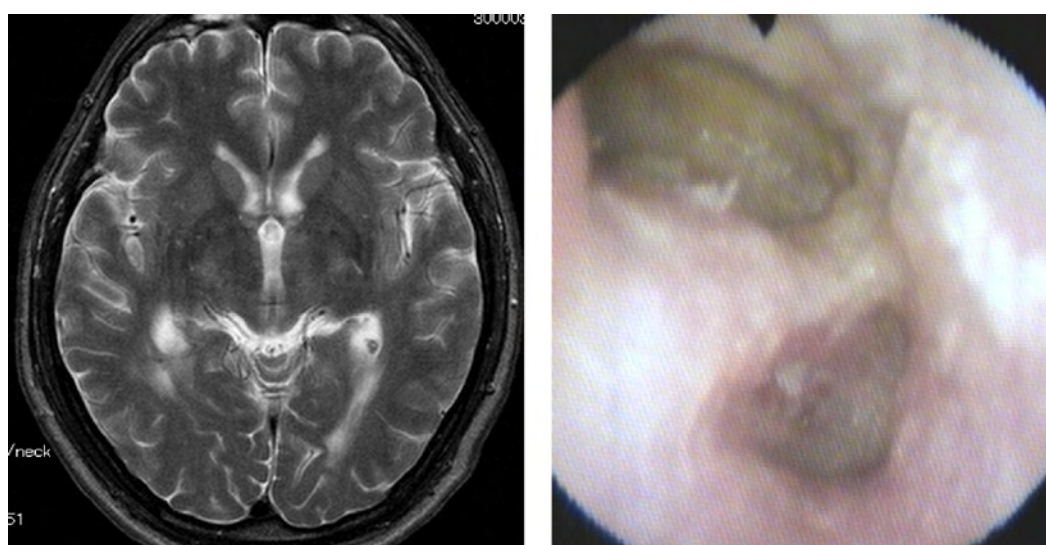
A. Axial section MRI. Brain abscess has disappeared. B. No recurrence of a cholesteatoma.
